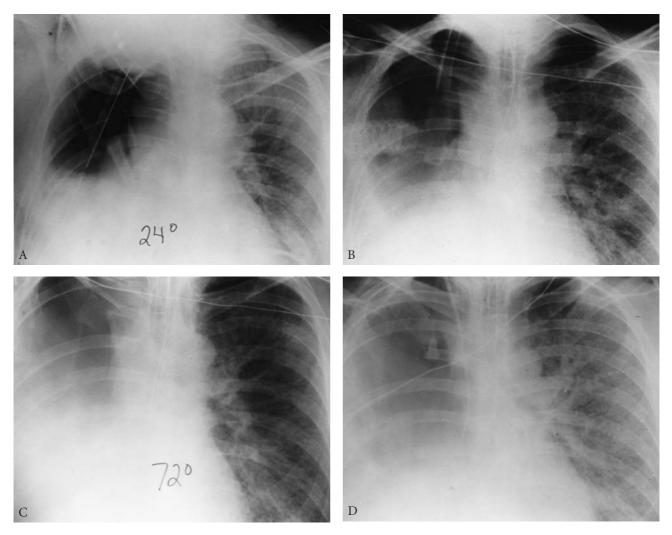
Development and progression of "postpneumonectomy pulmonary edema" to fatal acute respiratory distress syndrome. Uneventful right carinal pneumonectomy was performed for a squamous cell bronchogenic carcinoma invading the carina. A, The patient was extubated and clinically doing very well. At 24 hours, dyspnea appeared with diffuse left lung infiltrate. B, At 48 hours, the infiltrate had worsened. The patient was reintubated and ventilated. C, Progression at 72 hours. D, Chest roentgenogram at 120 hours, with marked worsening of the parenchymal infiltration. The patient continued to deteriorate and died 12 days after operation. This predated our use of nitric oxide treatment.
